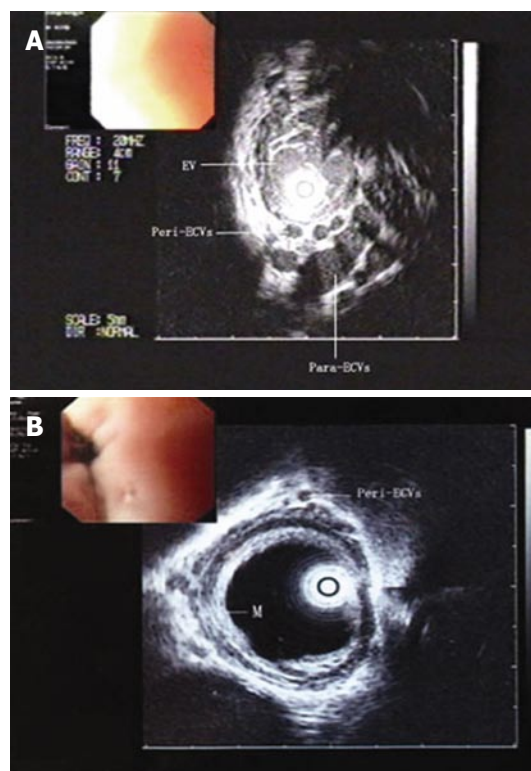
Alteration in appearance of ultrasound microprobe images. A: Before treatment, enlarged tortuous varices were found inside of the esophageal wall, while many small vessels adjacent to the muscularis externa formed a venous plexus. B: After treatment, anechoic areas inside and outside of the esophageal wall disappeared or remained only tiny, while the echo of mucosa and submucosa of the esophagus enhanced. EV: Varices inside of the esophageal wall; Peri-ECVs: periesophageal collateral veins; Para-ECVs: Paraesophageal collateral veins; M: Esophageal mucosa.
